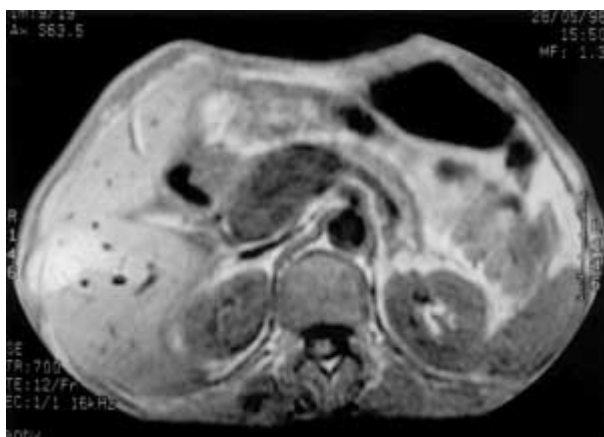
MRI appearance of the portal vein aneurysm.
